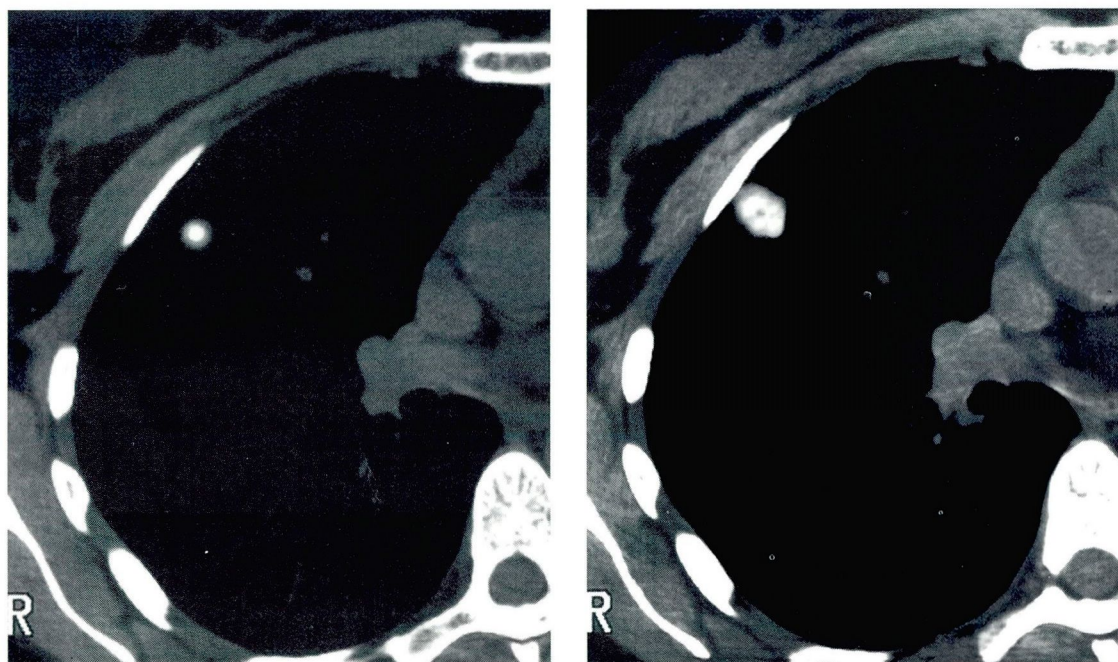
Computed tomography scans demonstrate dense, central “bull’s eye” (left) and “popcorn” patterns of pulmonary nodule calcification.
